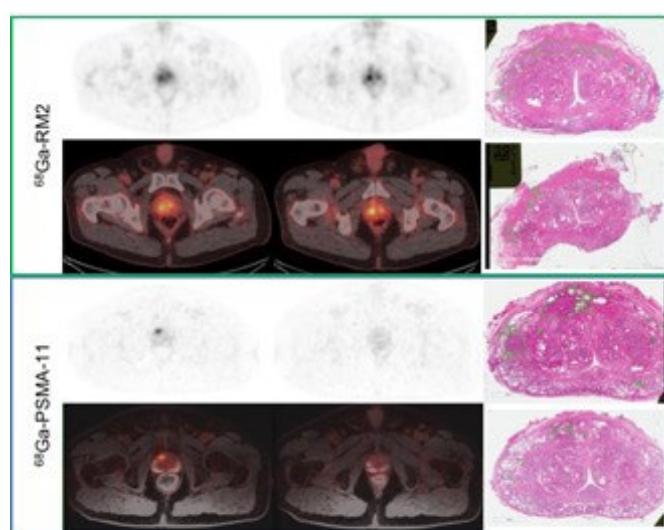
73 year-old man with bilateral prostate adenocarcinoma, Gleason score 3+4. Both the lesion seen on ^{68}Ga -RM2 and the lesion seen on ^{68}Ga -PSMA-11 were positive for PC.
